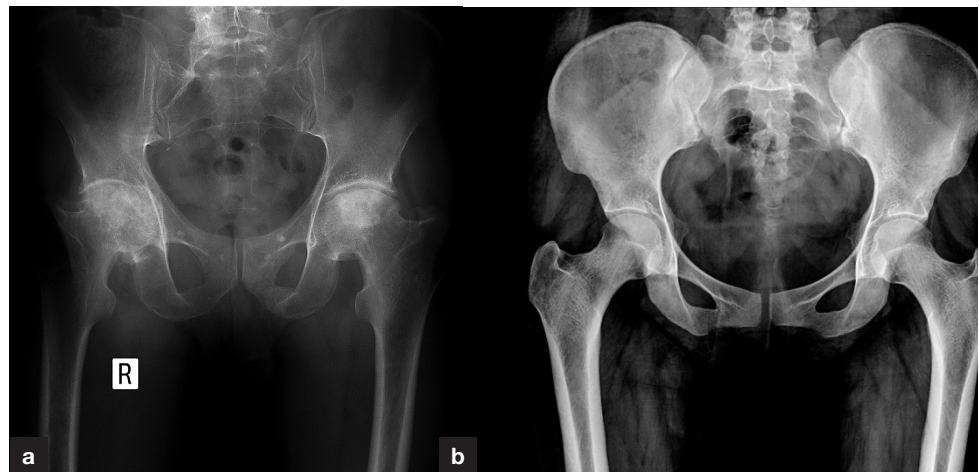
Radiographs showing (a) osteoarthritis of hips and (b) normal hips.
